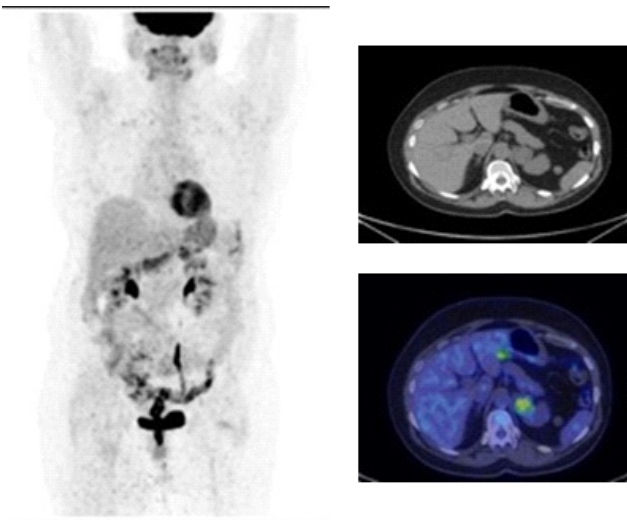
A 58 year old woman. Abdominal CT: left adrenal incidentaloma. Fluorine-18-FDG PET/CT: occasional typical uptake in the left adrenal gland.
